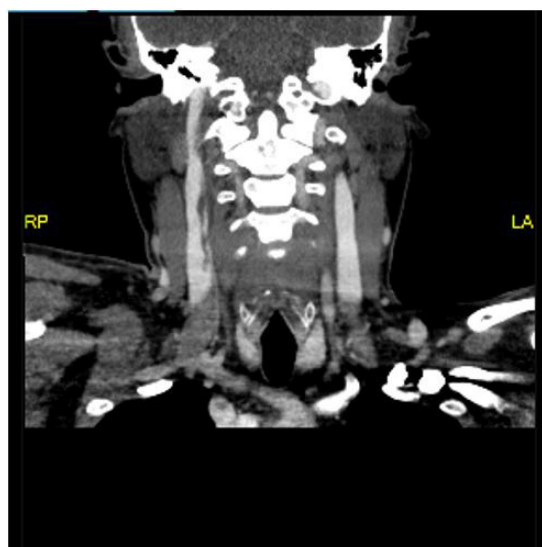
Contrast-enhanced neck computed tomography revealed venous thrombosis involving the sigmoid sinuses, both internal jugular veins, and the deep cervical veins.
